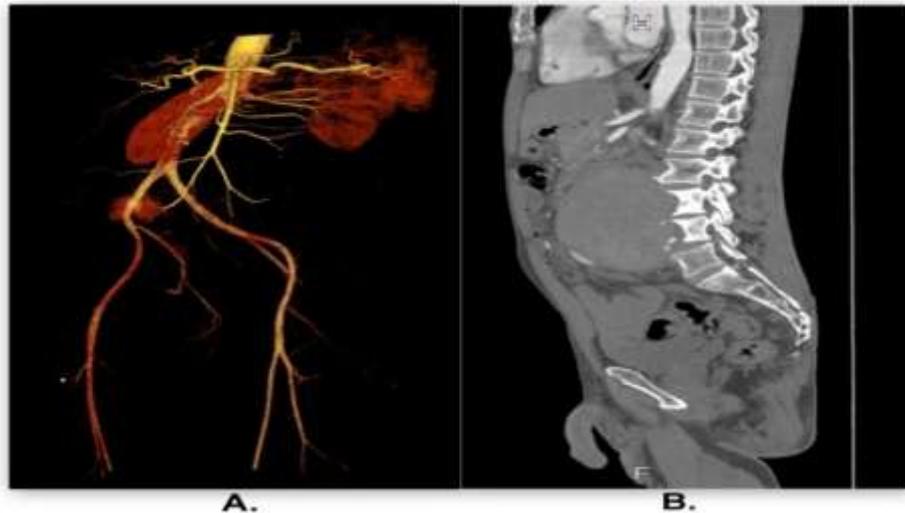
(A) 3D reconstruction of CT angiography showing pseudoaneurysm of infrarenal abdominal aorta and right common iliac artery with its extent. The distance between neck of pseudoaneurysm from renal artery and aortic bifurcation is well visualised. (B) Saggital view shows anterior displacement of abdominal aorta and erosion of L3-4 vertebrae due to compression by pseudoaneurysm.
